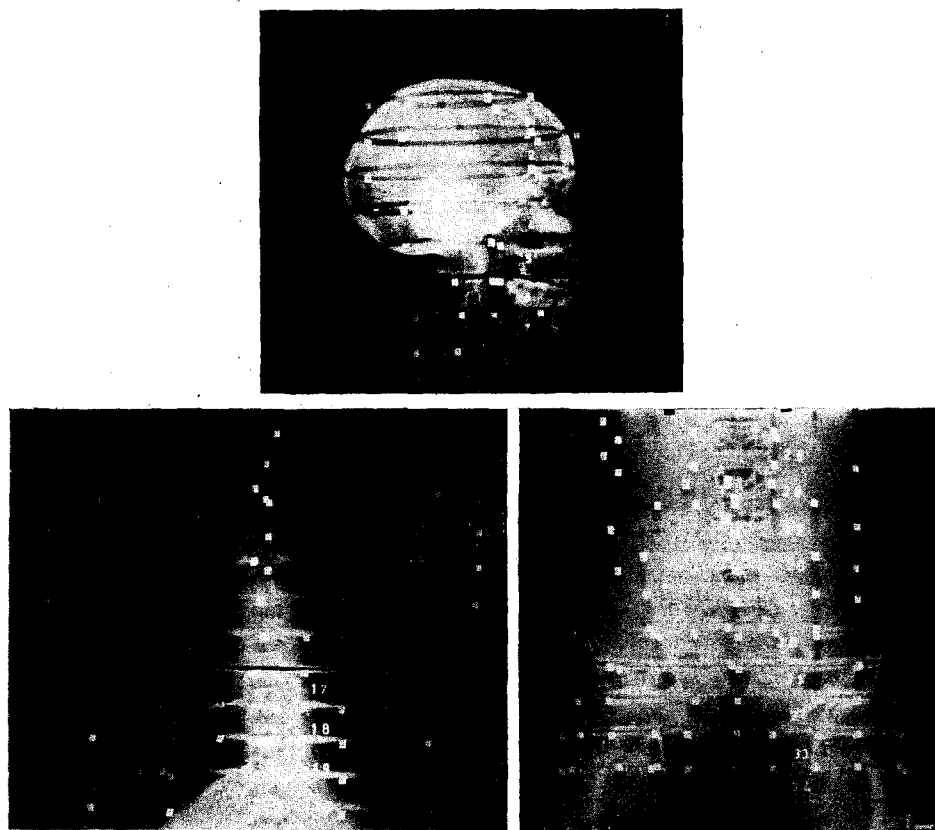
Radiographies du mannequin "Rando" avec positionnement des détecteurs internes.
